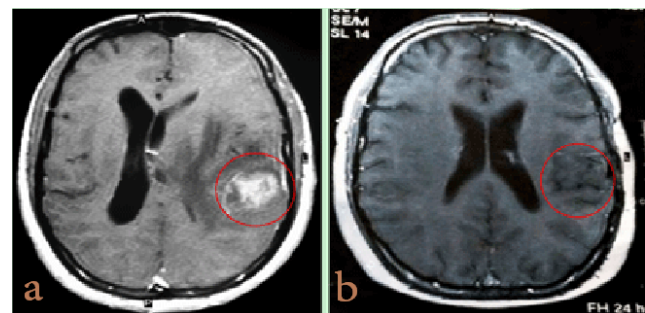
(a) MRI in T1 after Gd-DTPA infusion in axial plane shows an area of enhancement in GBM in the left parietal area; (b) MRI performed 1 year after the end of chemo-radiotherapy shows a dramatic response of the tumour T1 axial plane after Gd-DTPA infusion. MRI: magnetic resonance imaging; GBM: glioblastoma multiforme
